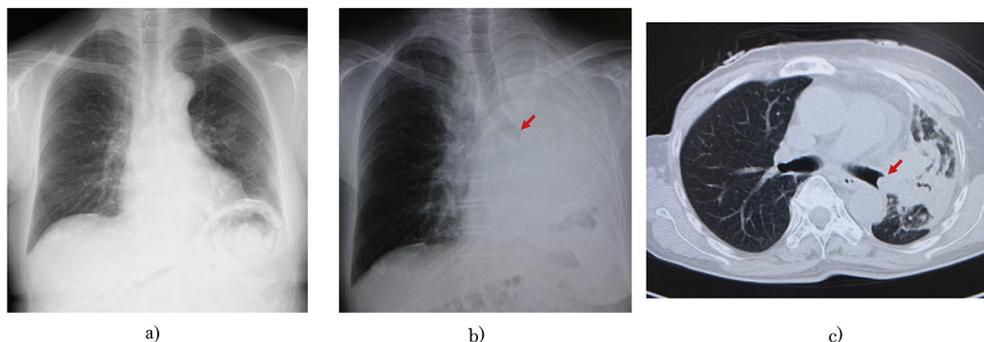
Chest X-ray and computed tomography (CT) findings. (a) Chest X-ray image obtained 3 months before admission showed pleural calcification near her left diaphragm and left mid-lung field. (b) Chest X-ray, and (c) CT images obtained on admission revealing obstruction of the left main bronchus by the tumor and atelectasis of the lung (red arrow).
